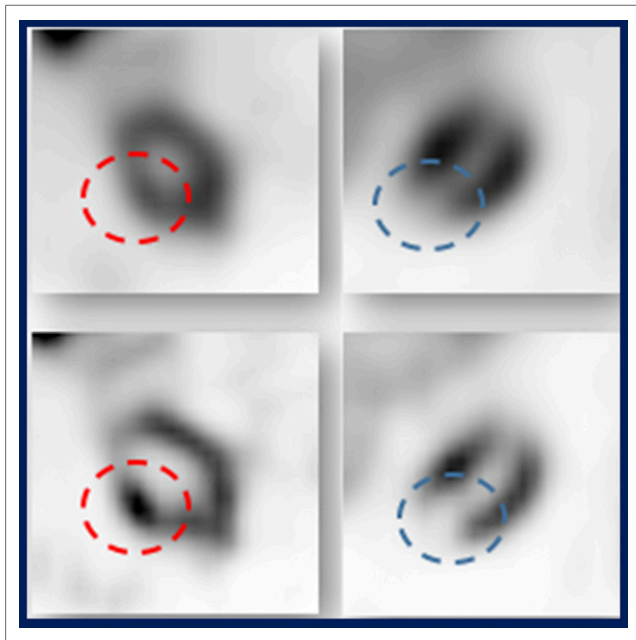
Quantitative SPECT/CT ^{99m}Tc -sestamibi renal imaging reconstructions (bottom) compared with those from the conventional Flash-3D algorithm (top) in hot (left, oncocytoma) and cold (right, renal cell carcinoma) masses.
